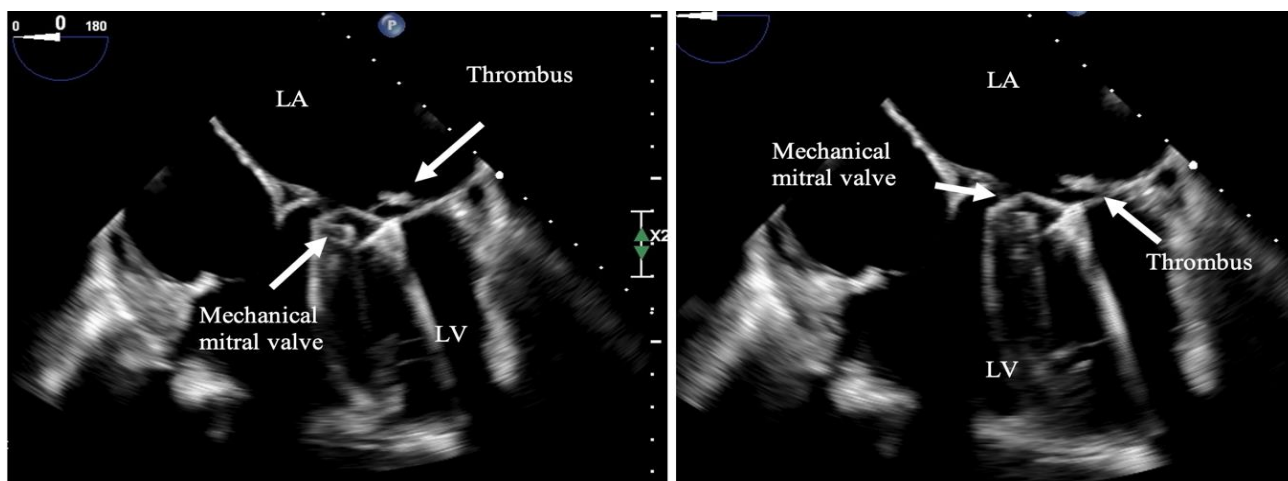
Transesophageal echocardiography reveals a mitral valve mass consistent with valve thrombosis. LA Left atrium. LV Left Ventricle.
